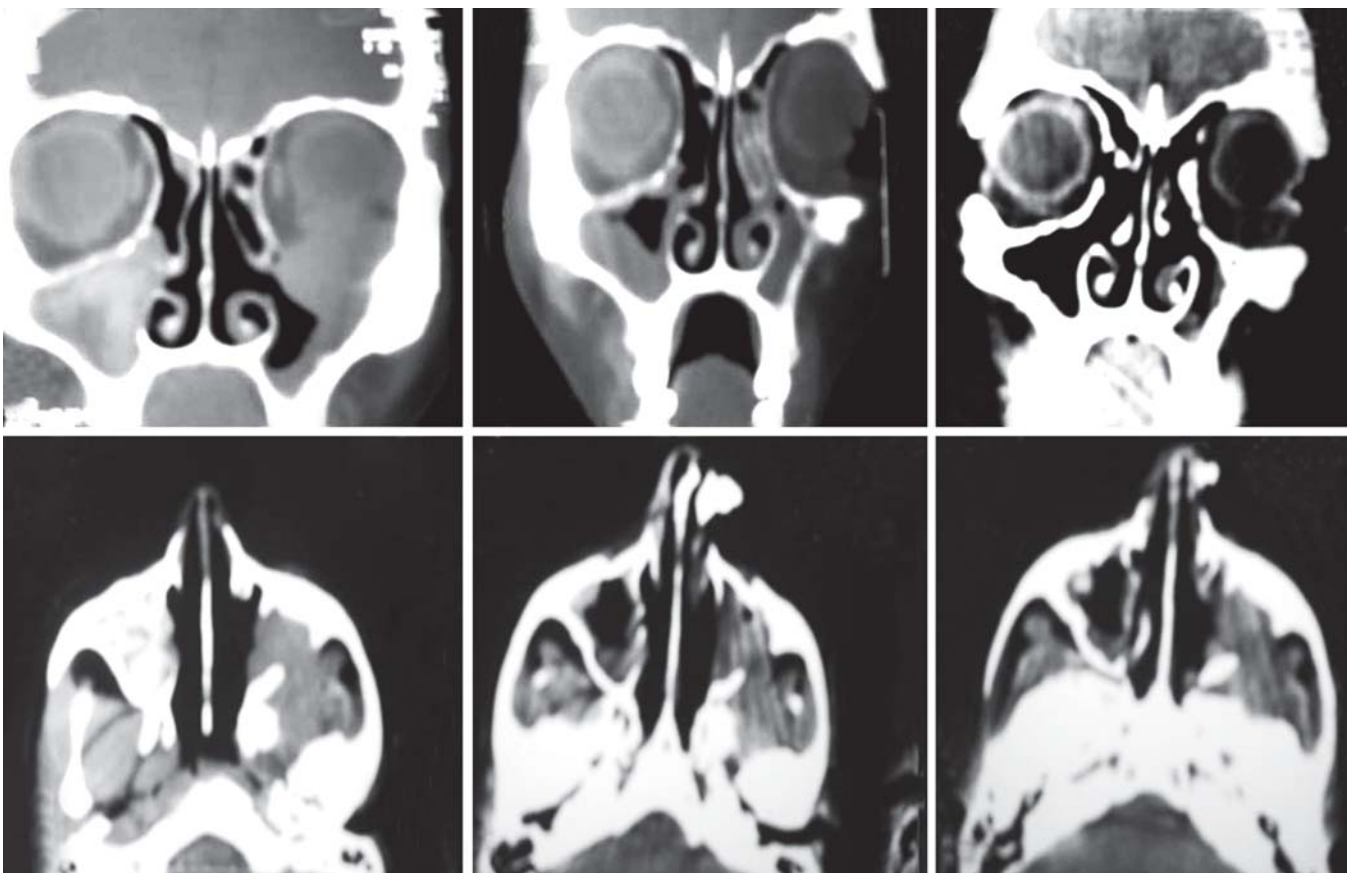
CT scan nose, PNS, orbits (axial and coronal sections) showing response to treatment with voriconazole in chronic invasive sinus aspergillosis
